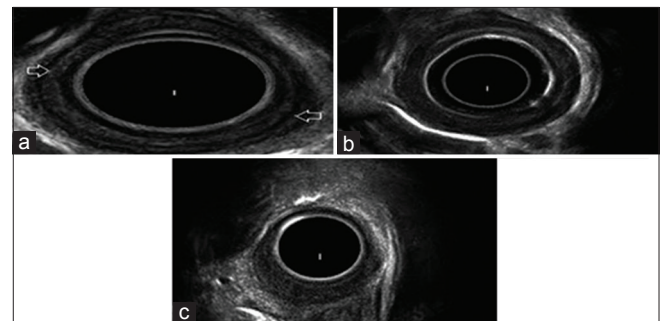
Endoscopic ultrasonography images of benign esophageal stricture reproduced from Rana *et al.*^[8] (a) Endoscopic ultrasonography in a patient with peptic stricture showing the involvement of the mucosa and submucosa. Muscularis propria is seen as hypoechoic layer (arrows). (b) Endoscopic ultrasonography in a patient with corrosive stricture showing involvement of the muscularis propria of esophagus with thickened esophageal wall. (c) Endoscopic ultrasonography in a patient with postradiation stricture showing involvement of all the layers of esophagus with thickened esophageal wall
